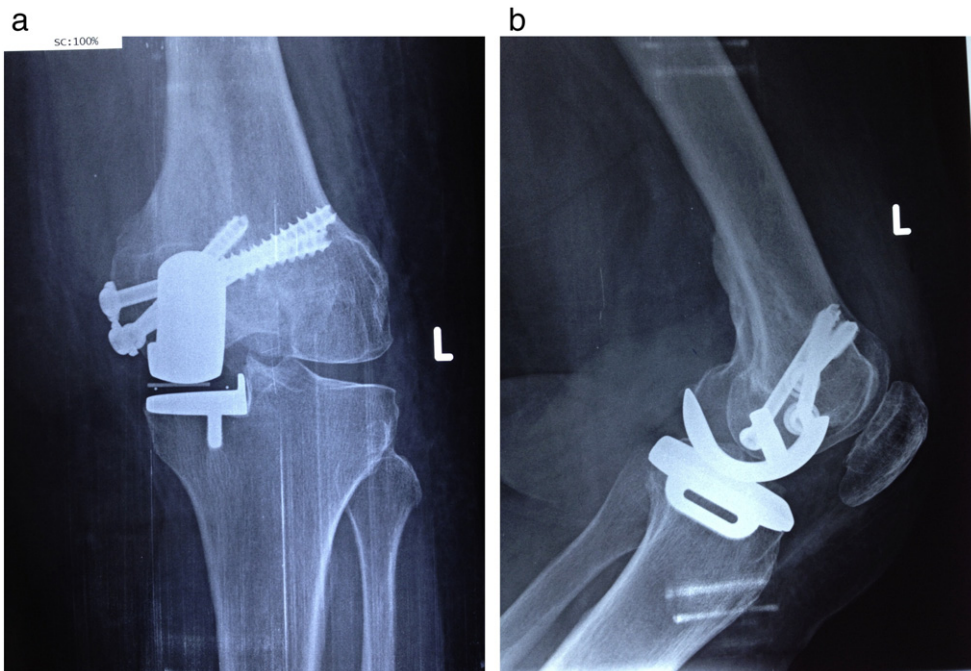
a) Anteroposterior X-ray view 6 weeks after surgery. b) Lateral X-ray view 6 weeks after surgery.
